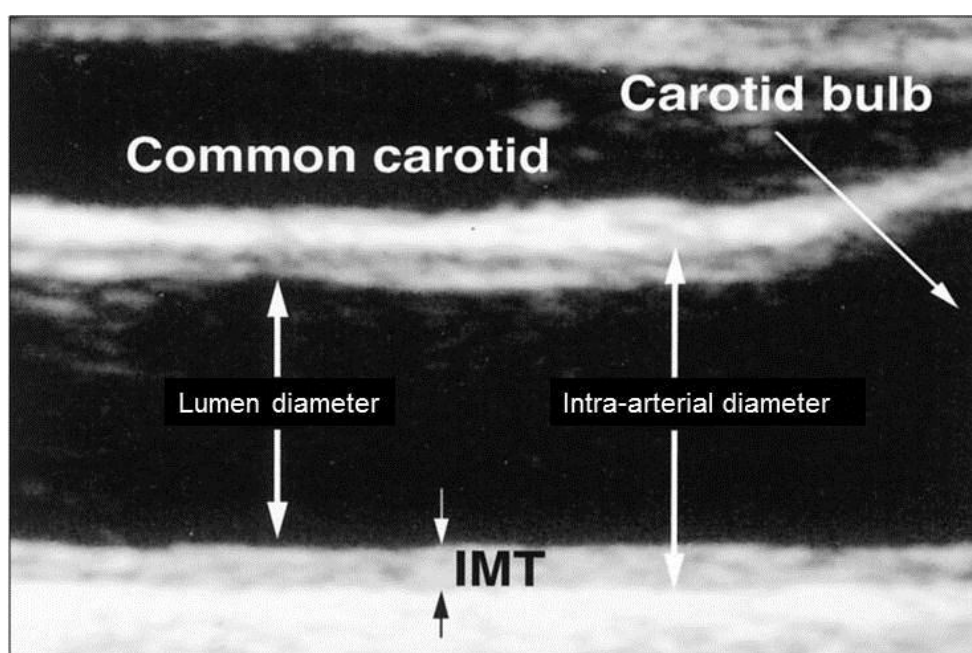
An ultrasound image of the carotid artery (IMT – intima-media thickness).
